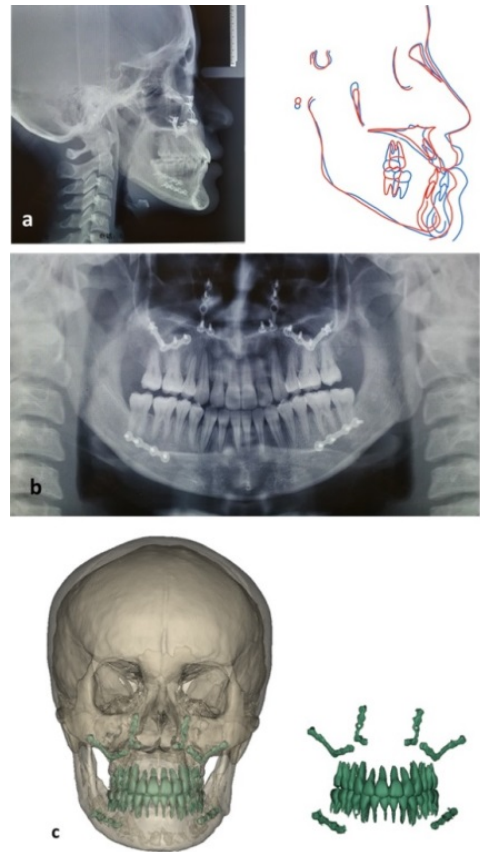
Post-treatment radiographs. a: posttreatment lateral cephalogram and pre- and posttreatment 2D superimposition (blue: pre-treatment; red: post-treatment); b: panoramic radiograph. c: CT scanning and 3D reconstruction of skull, dental occlusion and titanium plates. We could see there was a safety space between titanium screws and the roots of bilateral lower second molars.
